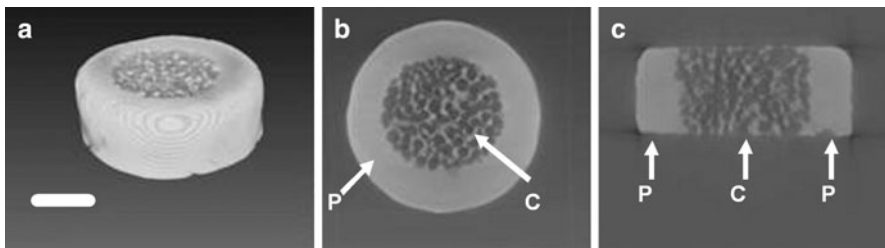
Micro CT images of a long-bone-like β -TCP graded scaffold with Peripheral dense zone (P) and Central porous zone (C) with 600–800 μm pore size. (a) 3D image; (b) coronal view of 2D image; (c) Sagittal view of 2D image. Bar = 2 mm
